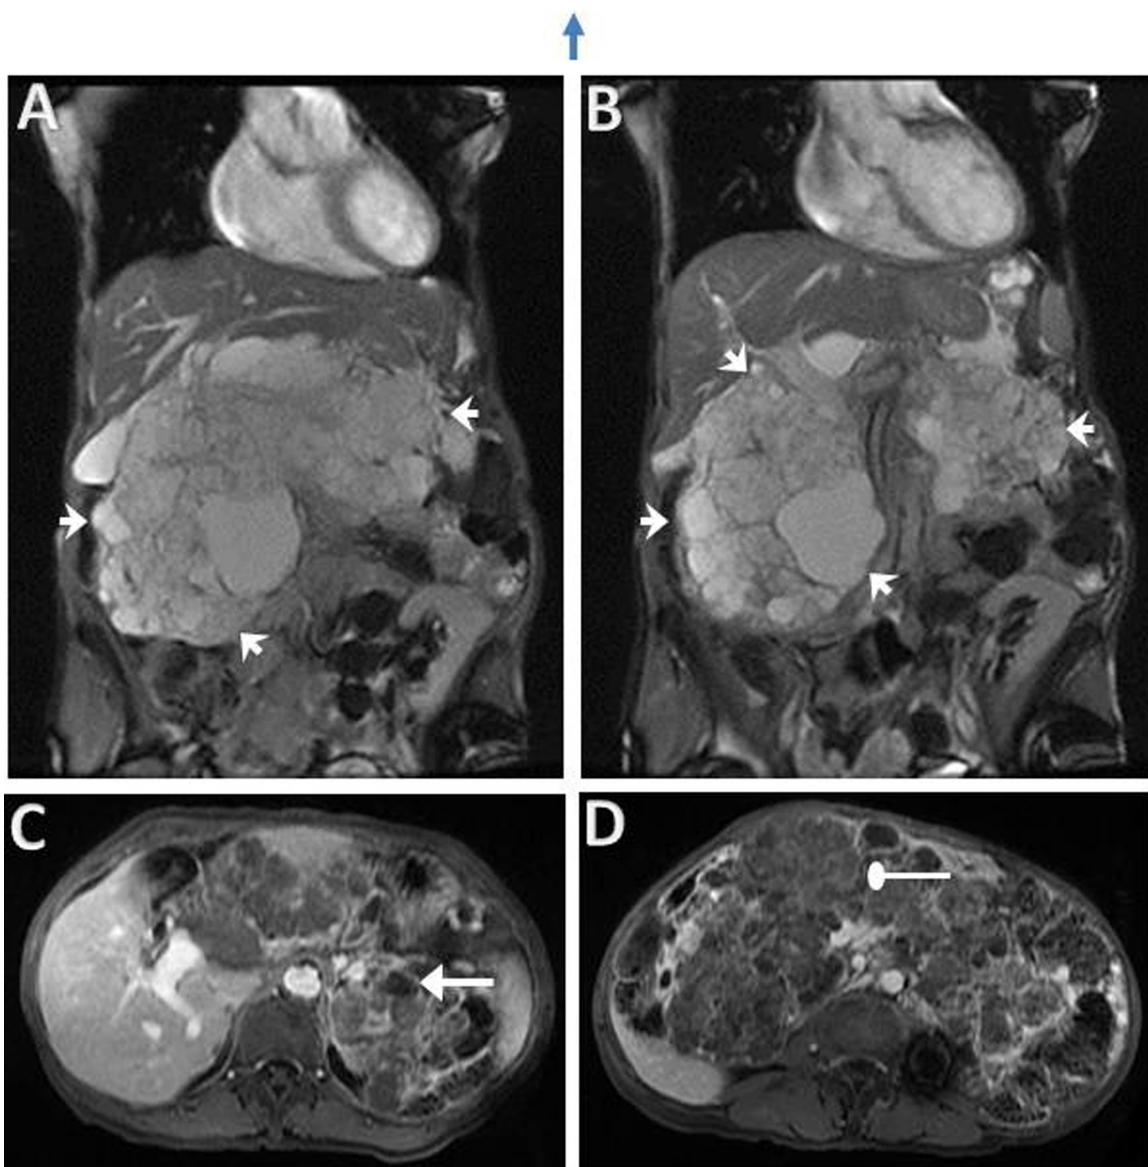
Magnetic resonance imaging of abdomen (panel A–D). Arrow head: multiple pancreatic cysts; single arrow: benign simple cysts; oval arrow: serous cystadenomas.
